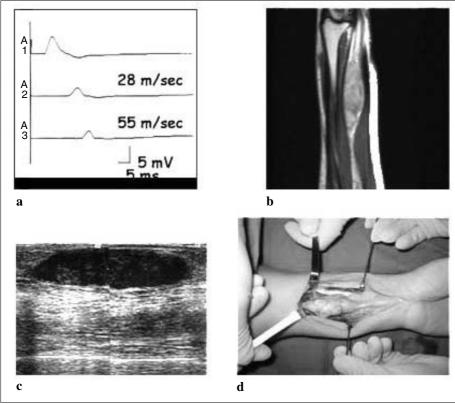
Case 1*. a Motor nerve conduction study of the median nerve: focal median motor slowing at the distal third of the forearm with conduction block. b T1-weighted gadolinium-enhanced MRI of forearm: the image shows an ovalar structure along the median nerve. c Ultrasonography of forearm: hypoechoic ovalar structure along the course of median nerve. d Median nerve surgical findings
